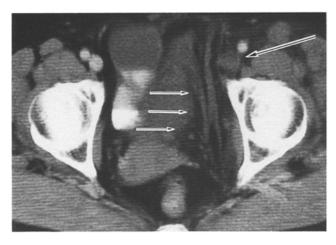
Computed tomography (CT) scan. The left iliac vein (long arrow) was dilated with a thrombus while a retroperitoneal hematoma (short arrows) was located in the left iliac fossa
